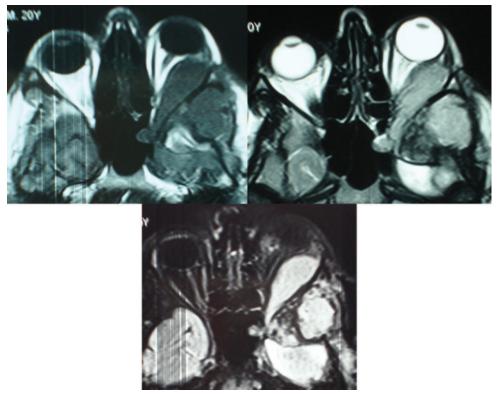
Orbital MRI: T1-weighted axial MRI showing the lesion with hypo signal intensity (left upper). T2-weighted axial MRI shows the lesion with hyper intensity (Right upper).T1-weighted with contrast and fat suppression shows contrast enhancement of the mass within the orbit and brain (lower).
